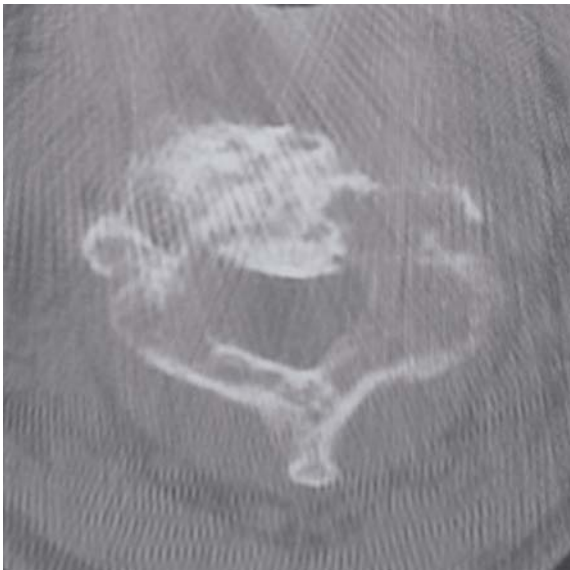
Posterior element involvement in TB of the cervical spine. Axial CT image of C2 vertebra shows marked reactive sclerosis and destruction of both anterior and posterior elements.
